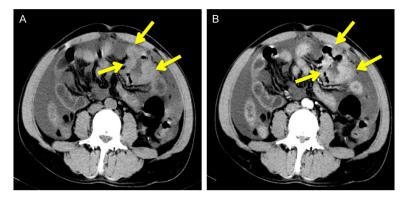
The small intestine lesion on computed tomography (CT). A. Asymmetric thickening of small intestine wall on plain CT image (arrows). B. Dynamic contrast CT showed markedly enhancement of small intestine wall (arrows).
